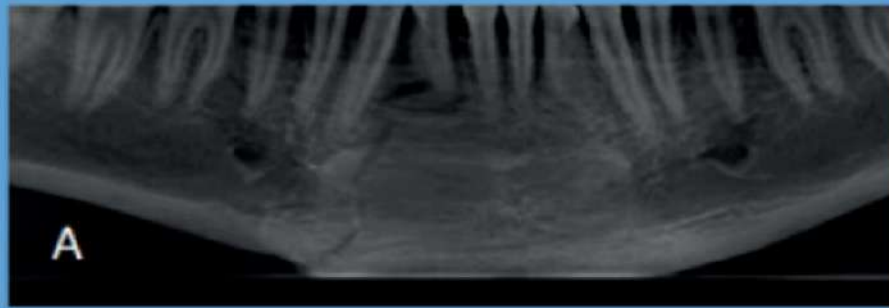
Three Dimensional visualization of right parasymphysis fracture of mandible on CBCT scan – Panoramic view (A), Axial view (B) and IVR (C, D, E).
